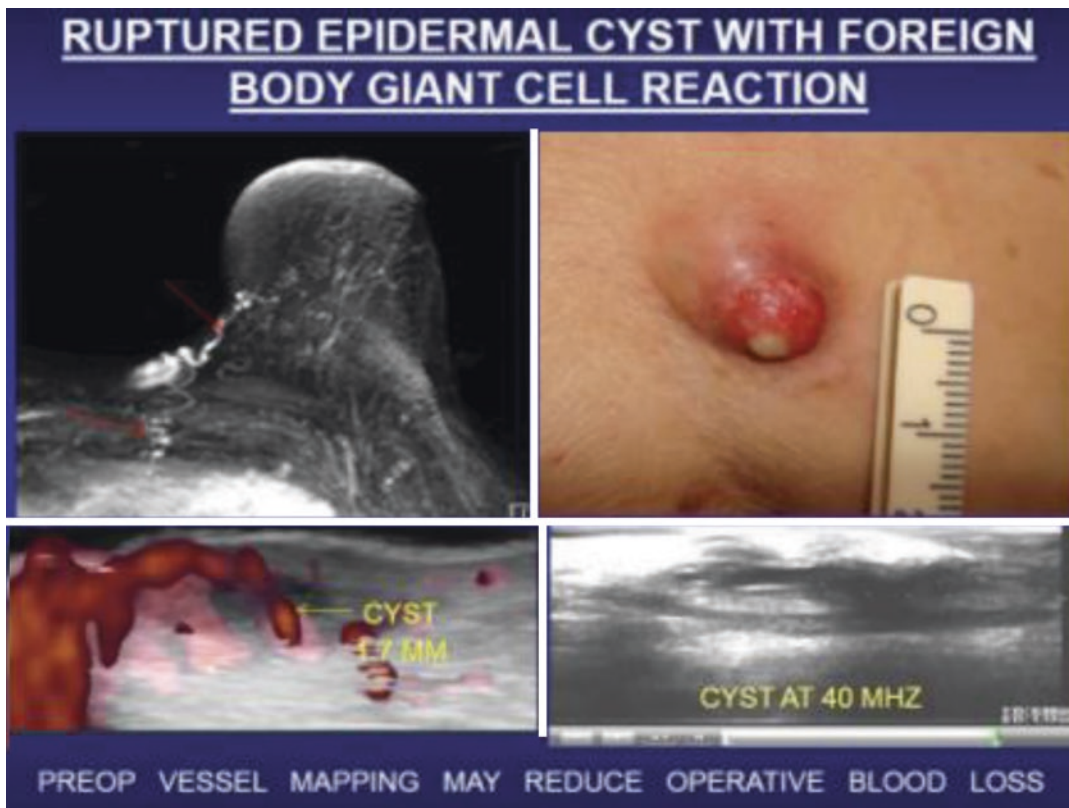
Ruptured intradermal cyst mimicking breast cancer on MRI, Doppler, sonogram, and 3D
